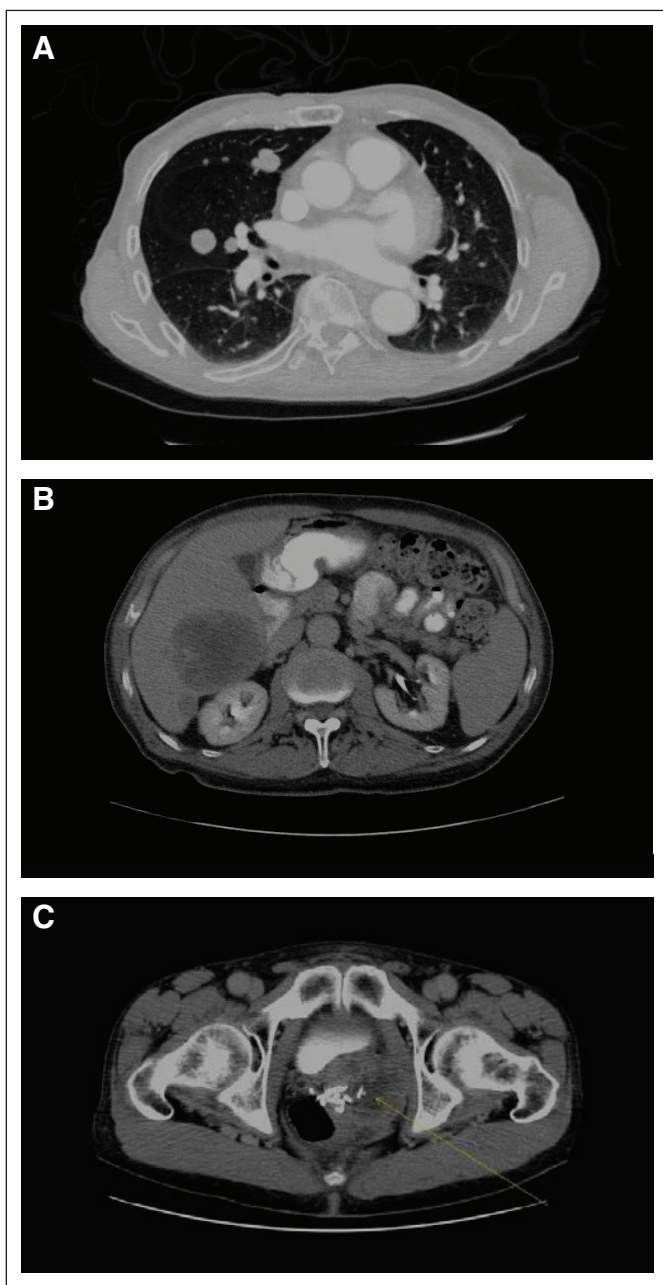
(A) Computed tomography (CT) scan image showing bilateral lung metastases. (B) CT scan image showing large liver metastasis. (C) CT scan image showing soft tissue mass (arrow) arising from the prostatectomy bed.
